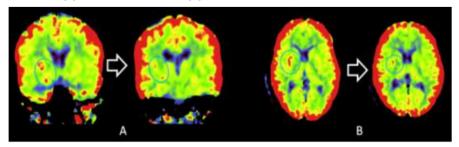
Head CT Angiography before and after cerebral bypass surgery procedure. Image recontruction using application cerebral blood volume, coronal view (A) and axial view (B), showed prominent blood volume in the right basal ganglia before surgery and that prominent blood volume is reduced after surgery.
